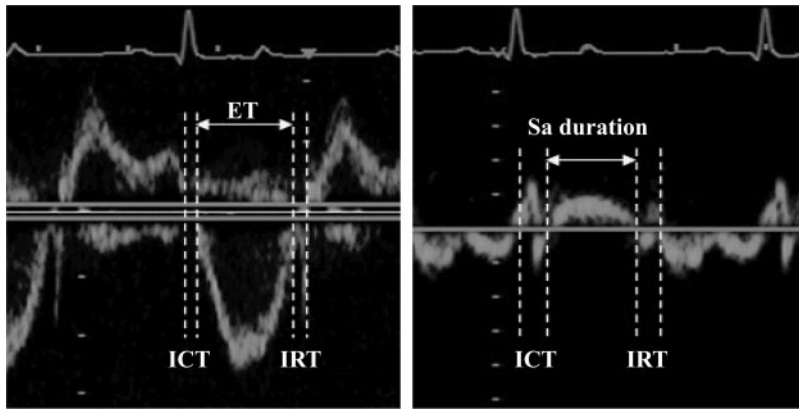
Pulsed Doppler (PD)-derived myocardial performance index (MPI; left) and tissue Doppler-derived modified MPI (right). ET, ejection time; ICT, isovolumic contraction time; IRT, isovolumic relaxation time; Sa, ventricular systolic velocity.
